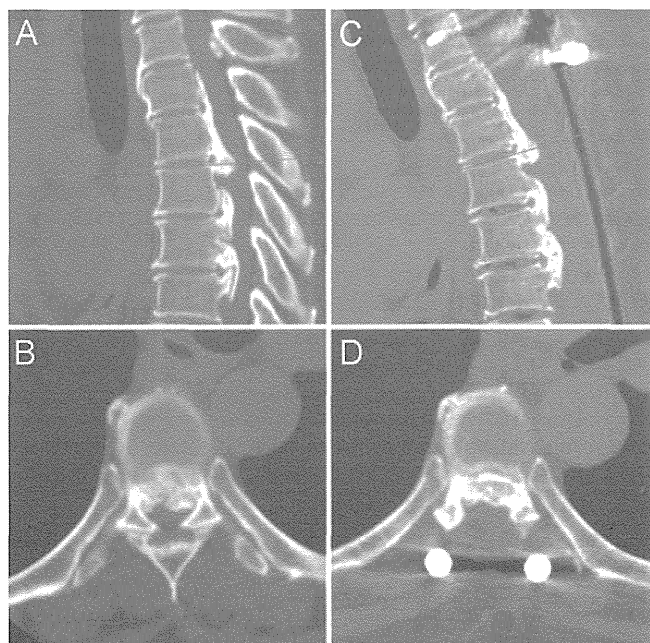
A: The level of the most obvious protrusion of ossification was determined as previously described (*line*). B: Preoperative axial view of ossification at the determined level. C: The same level was selected on postoperative CT scans. D: Axial postoperative CT scan showing enlargement of the area of ossification.
